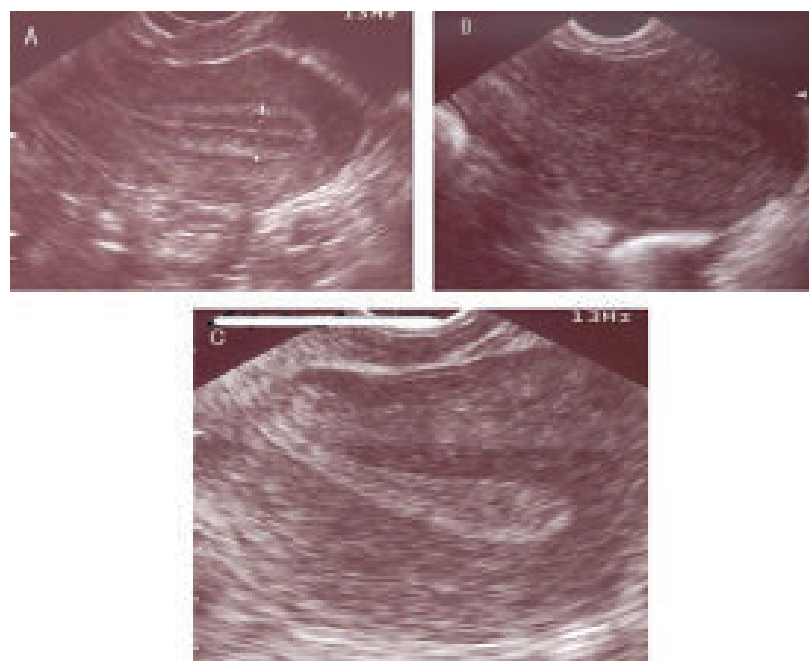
TVS showing Dominant follicleFigure 3: TVS showing Endometrial thicknessFigure 4: Longitudinal ultrasound images demonstrate the endometrial pattern
